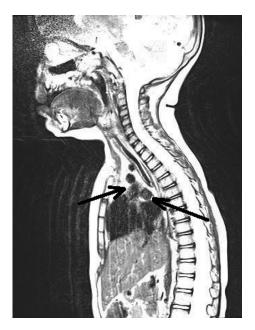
Presentation of the tumor mass with CT scan
